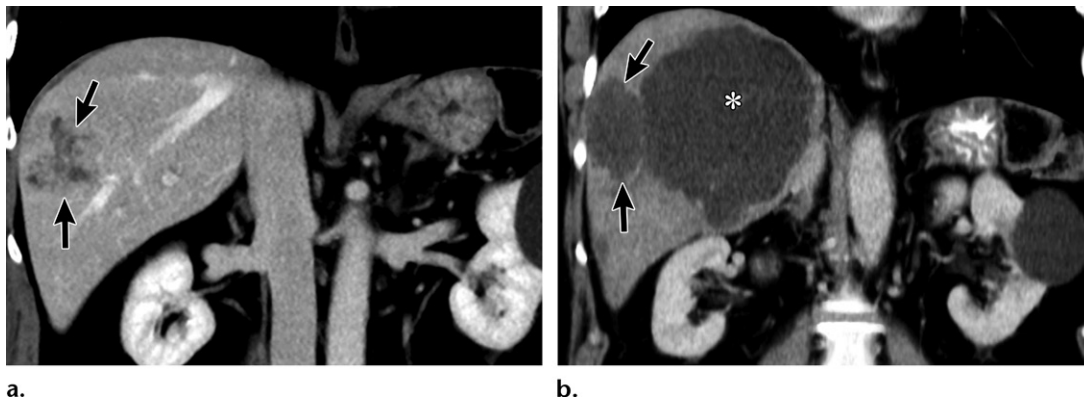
Biloma in a 70-year-old man with a metastatic neuroendocrine tumor. (a) Coronal pretreatment portal venous phase CT image shows the metastatic lesion (arrows). (b) Coronal post-TARE portal venous phase follow-up CT image shows a complete response of the treated lesion (arrows). Also note the large well-defined fluid-filled area (*) adjacent to the lesion, representing a biloma.
